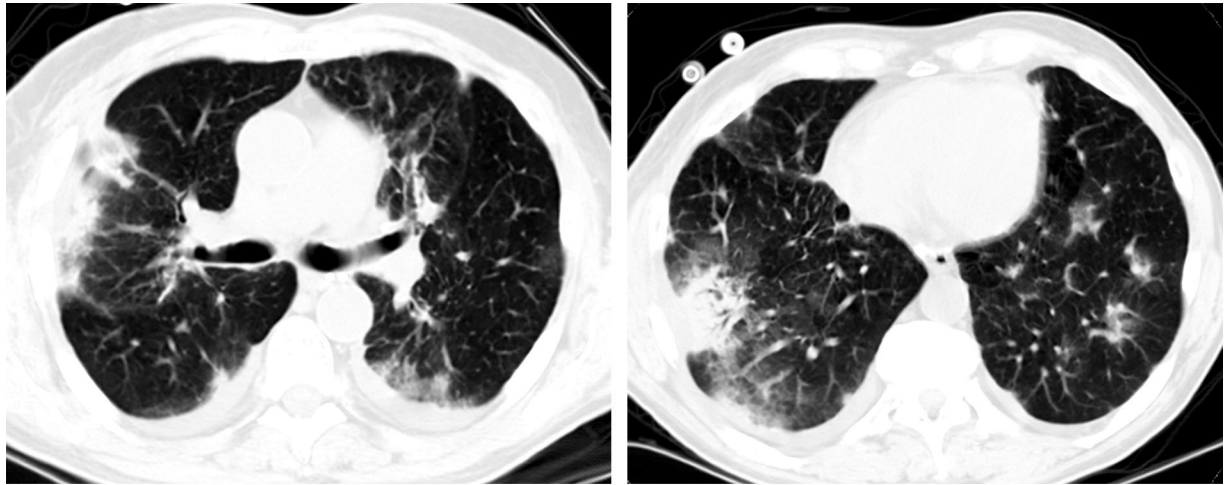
Cryptogenic organizing pneumonia in the late posttransplantation period. CT scans show peripheral consolidation (a) and increased centrilobular attenuation (b).
